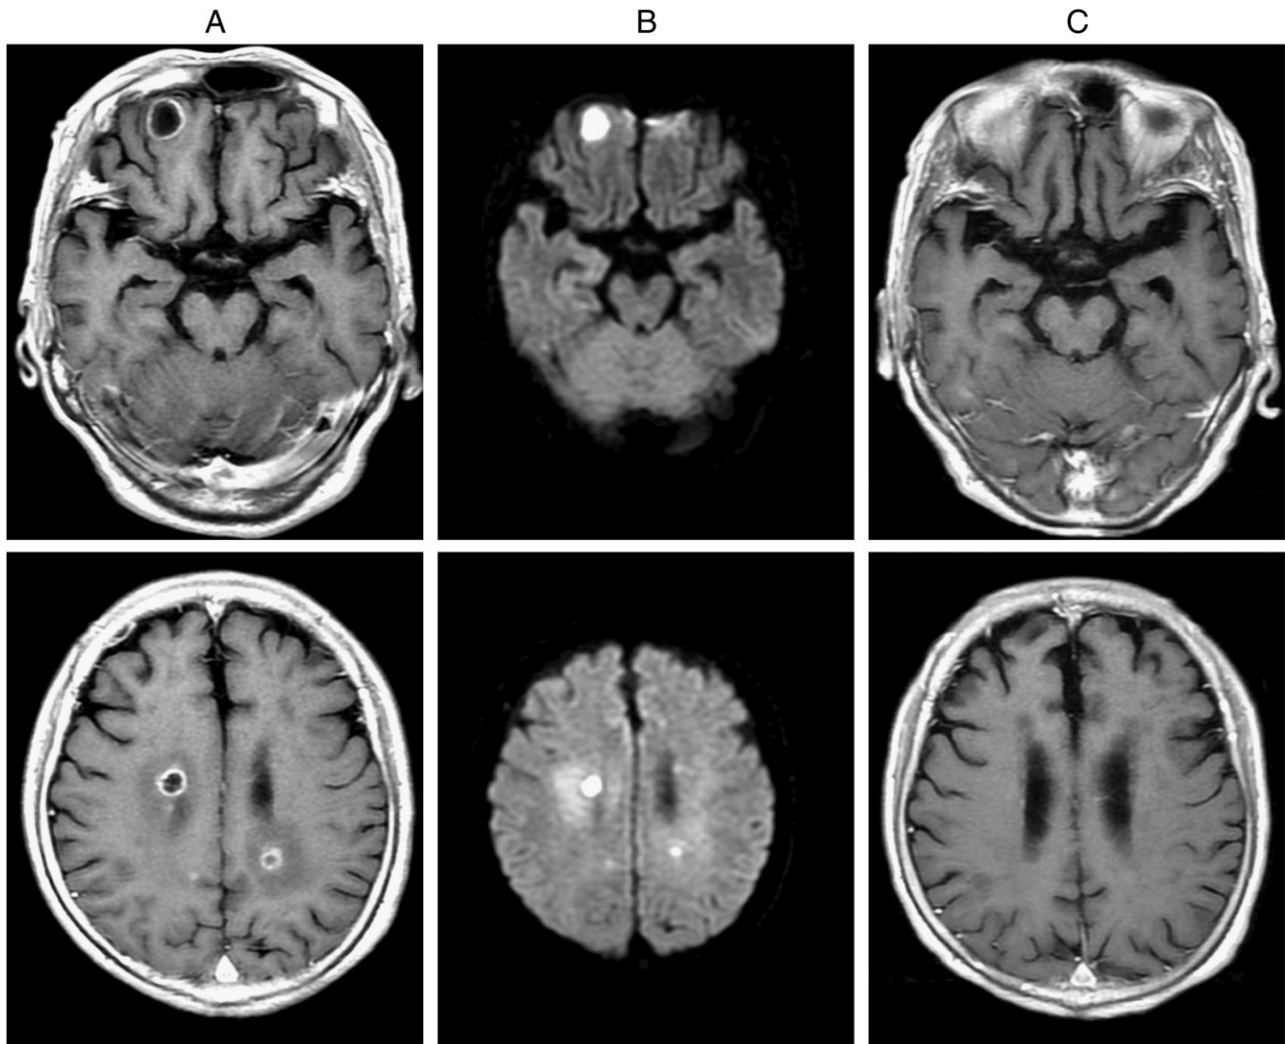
Gd-DTPA-enhanced MRI of the brain revealed multiple ring-enhanced masses with surrounding edema (A), and diffusion-weighted MRI (DWI) revealed that these were high-intensity lesions (B). These lesions had nearly disappeared after 6 months of antibiotic treatment (C).
